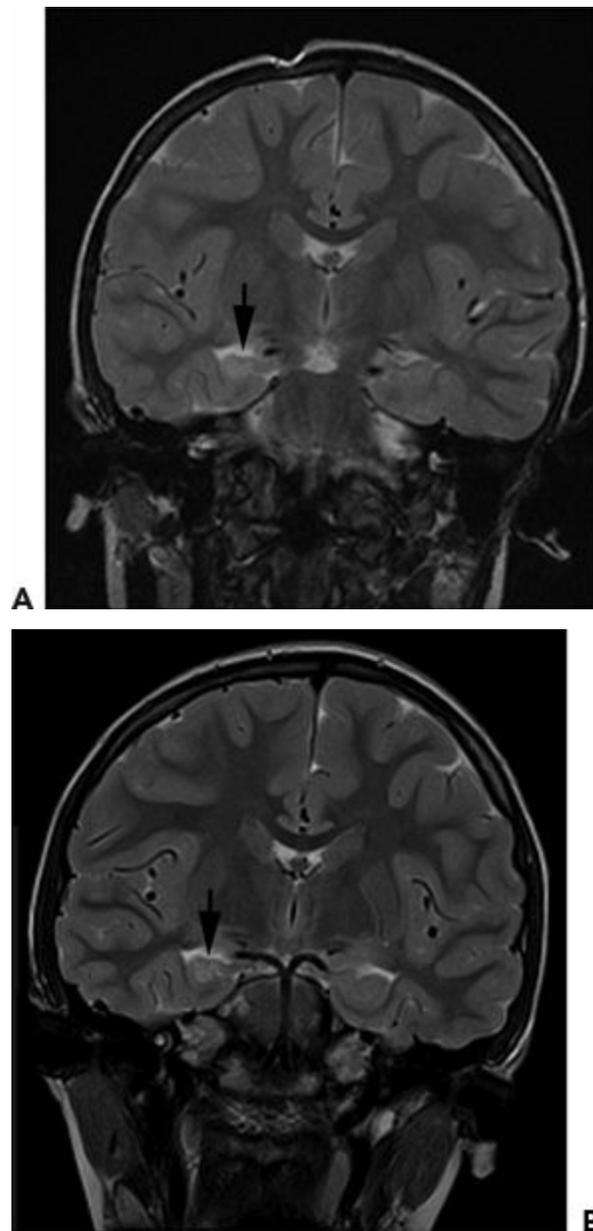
Brain MRI of a child that had a 2-hour febrile convulsion. A: Coronal image obtained from brain MRI performed <6 months after febrile status epilepticus. Image shows abnormal high T2 signal in the right hippocampus with slight volume loss. B: Coronal image obtained from brain MRI performed approximately 5 years after febrile status epilepticus. Image shows increased T2 signal intensity within the right hippocampus with associated slight volume loss.
